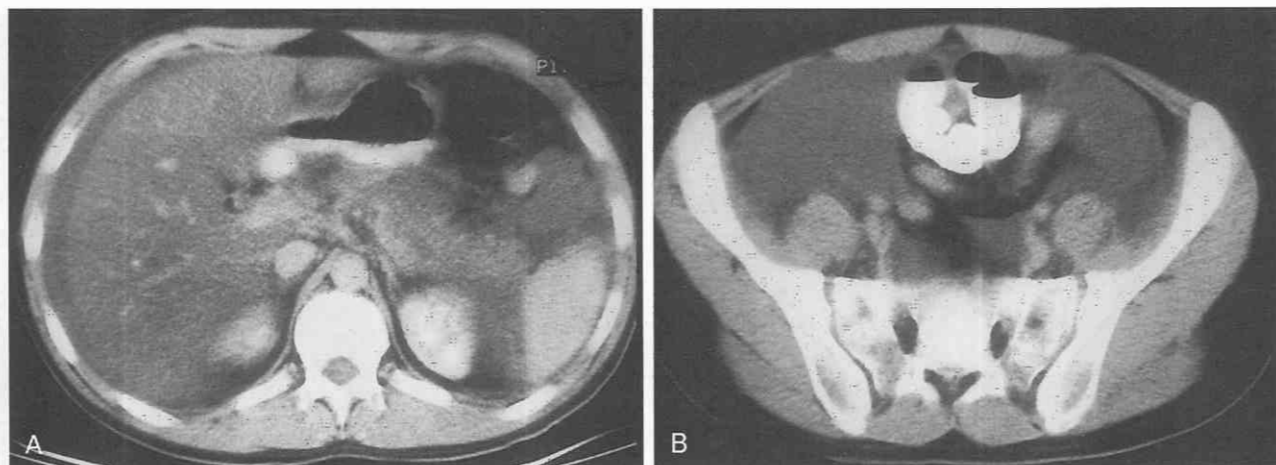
Acute pancreatitis with free peritoneal fluid. A, CT scan through the upper abdomen in a patient with acute pancreatitis demonstrates ill definition of the pancreatic margins and fluid in the anterior pararenal space. B, CT scan through the pelvis in the same patient demonstrates a large amount of free peritoneal fluid.
